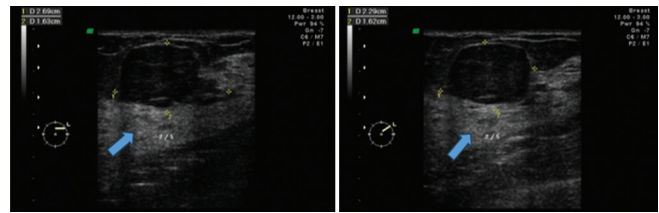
Breast ultrasound showing another new hypoechoic nodule at left 2/5
